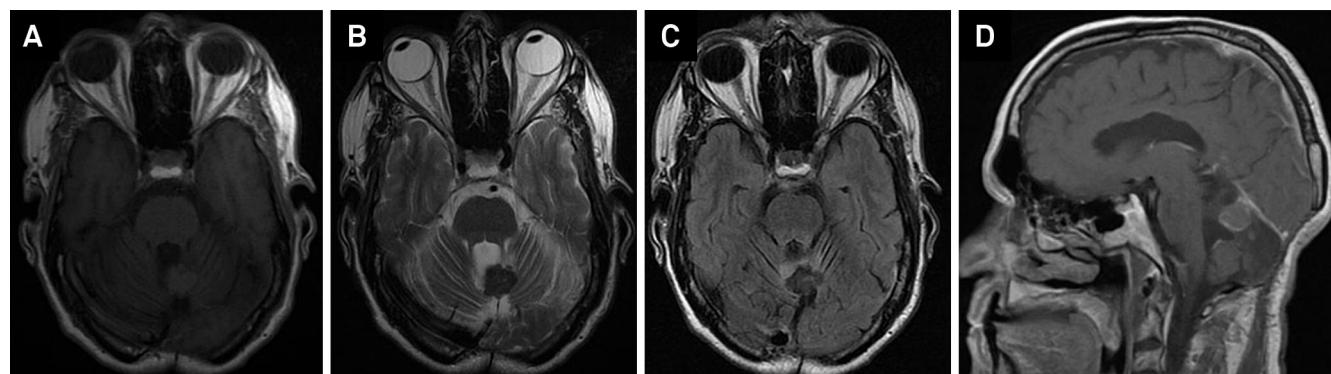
(A) Brain MRI disclosing a hyperintense lesion in the superior vermis on axial T1-weighted images; (B) hypointense on axial T2; (C) FLAIR-weighted sequences; and (D) with ring-enhancing on sagittal post-gadolinium T1-weighted images.
